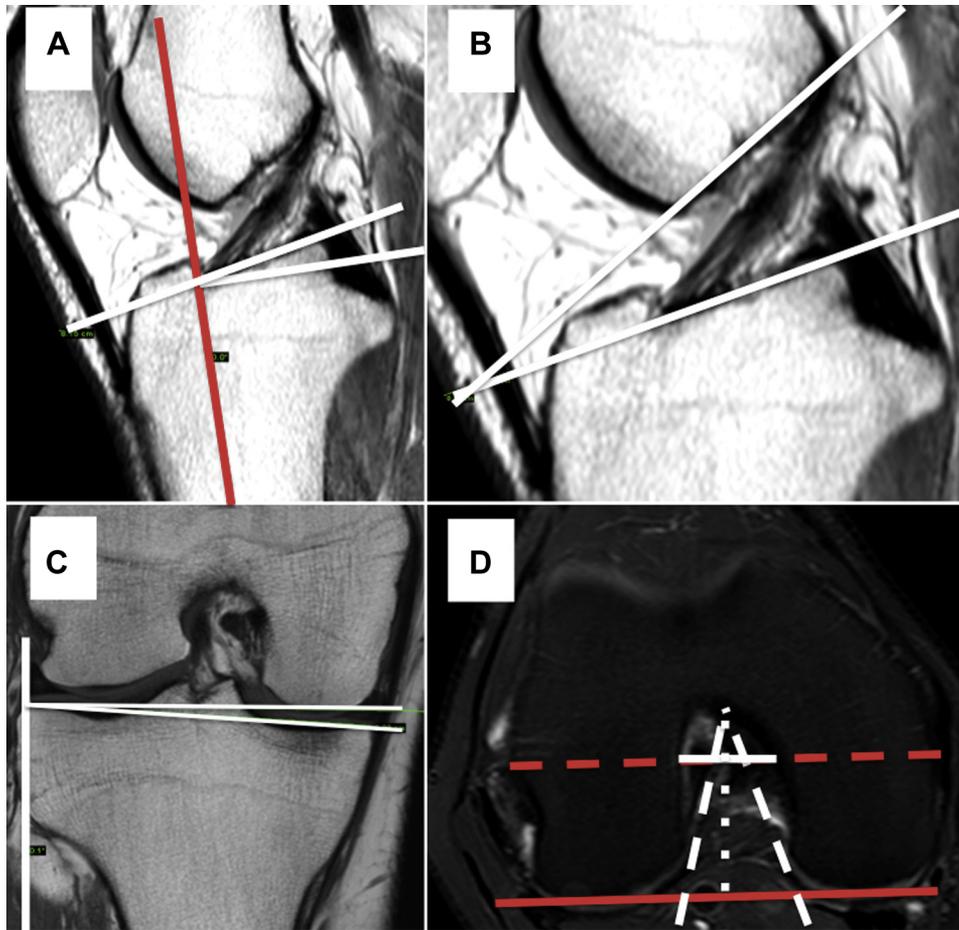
Summary of principal femoral and tibial parameters evaluated on magnetic resonance imaging. (A) T1-weighted sagittal magnetic resonance image of a right knee showing the anterior tibial slope, that is, the angle formed by the 2 white lines. A midpoint between the anterior and posterior cortex of the tibial diaphysis is taken and is joined to another midpoint at least 5 cm distally. This creates the longitudinal axis of the tibia (red line). The anterior tibial slope is then determined by the angle between a line passing through the anterior cruciate ligament tibial footprint (superior white line) and a perpendicular line (inferior white line) with respect to the longitudinal axis. (B) T1-weighted sagittal magnetic resonance image of a right knee showing the angle between the Blumensaat line and anterior tibial slope, that is, the angle formed by the 2 white lines. (C) T1-weighted coronal magnetic resonance image of a right knee showing the coronal tibial slope, that is, the angle formed by the 2 horizontal white lines. The longitudinal axis of the tibia is determined first (vertical white line), using the same method as described for the sagittal plane but taking the midpoints with respect to the medial and lateral cortex of the tibial diaphysis. The coronal tibial slope is determined by the angle between a line joining the peak points on the medial and lateral aspects of the tibial plateau (inferior horizontal white line) and a perpendicular line (superior horizontal white line) with respect to the longitudinal axis. (D) T2-weighted axial magnetic resonance image of a right knee showing the intercondylar notch dimensions: intercondylar notch width (solid white line), intercondylar notch angle (dashed white lines), and intercondylar notch depth (dotted white line). An axial plane showing the popliteal groove is loaded into the computer, and then the posterior bicondylar line is drawn. The intercondylar notch depth (dotted white line going from the top of the notch to the bi-epicondylar line) is used to calculate the intercondylar notch width (solid white line representing the distance between the medial and lateral femoral condyle walls at the anterior third of the intercondylar depth). The intercondylar notch angle is formed by the 2 lines going from the top of the notch to the most inferior aspect of the notch at the medial and lateral condyles. The red lines represent the width of the medial and lateral condyles.
